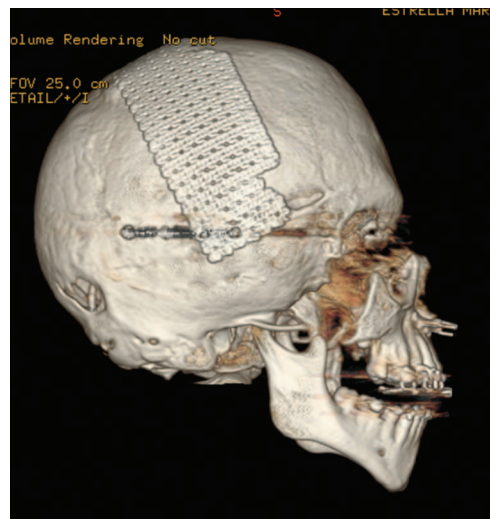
Postoperative computed tomographic image demonstrating maxillary advancement without disruption of the cranial base.
